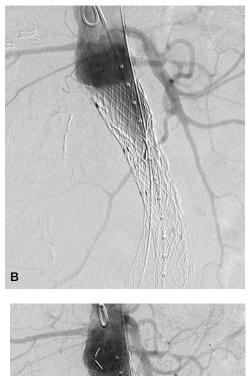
A. CT showing significant para-aortic hematoma in a patient who presented with back and abdominal pain 5 years following initial EVAR. B. Aortogram failed to reveal the site of rupture but did show significant migration treated with proximal aortic cuff extension (C).
